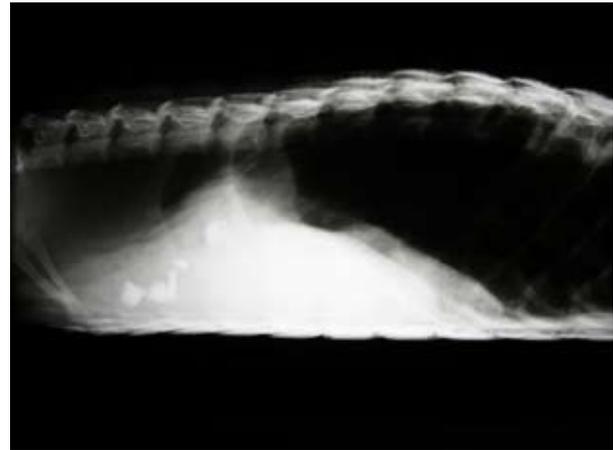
Radiography (LL) of the female brown caiman did not reveal any pathological findings
